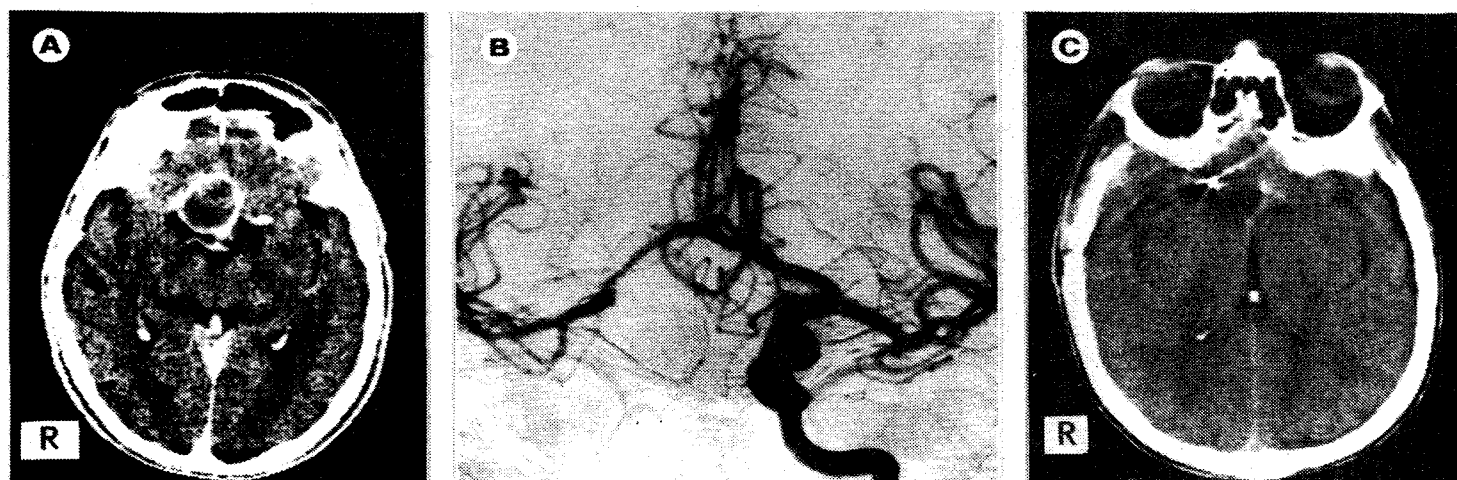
A—preoperative CT scan in patient 1, showing large mass with low-density centre and contrast-enhancing rim in right side of the suprasellar cistern; B—preoperative angiogram showing large avascular mass in suprasellar region, elevating proximal segments of both anterior cerebral arteries; C—postoperative CT scan showing a small extra-axial collection of fluid and air and a low-density area at the site of the obliterated giant aneurysm.
